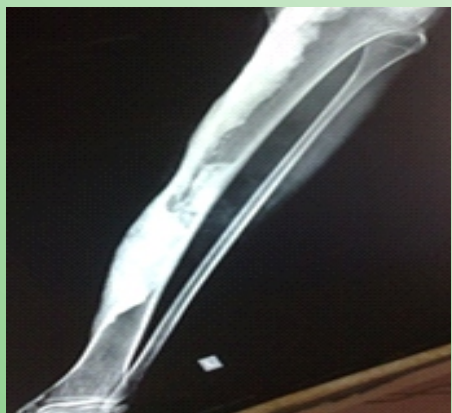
Full Length Leg Bone AP View X-ray.
